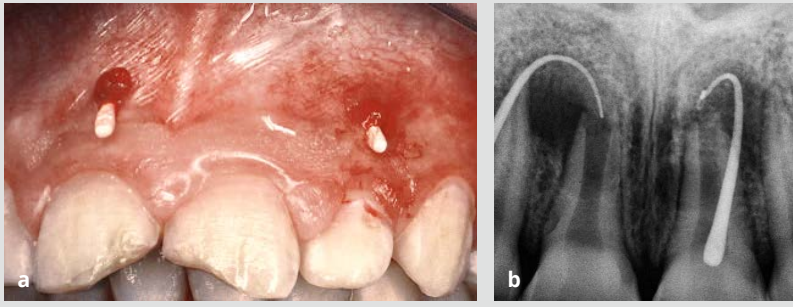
Sinus tract exploration. Sinus tracts should always be traced by (a) placing a gutta-percha in them and (b) exposing a radiograph. (c) Sinus tract may appear far away from the offending tooth.
